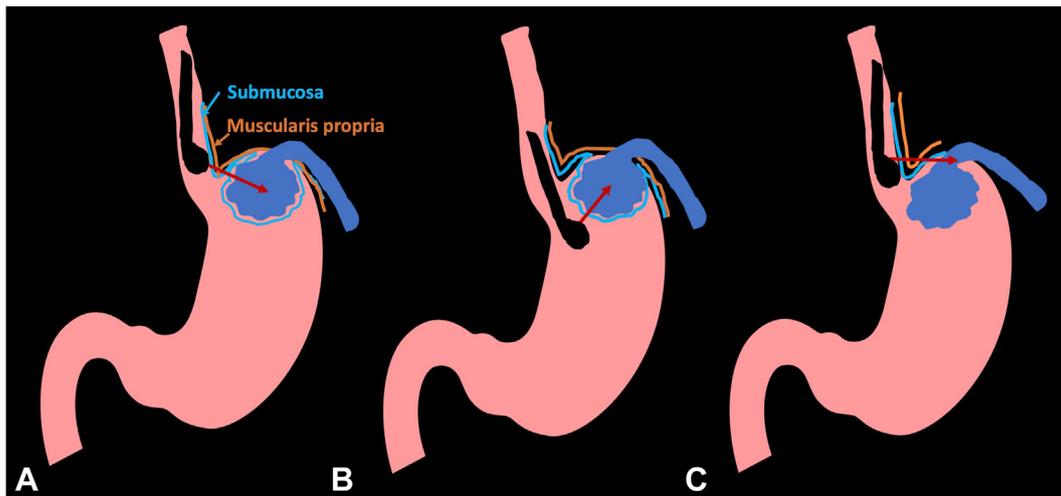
Various approaches of EUS-guided gastric variceal therapy. A, EUS-guided embolization of gastric varices via transesophageal (transmuscularis propria) approach: direct puncture of the varix and embolization technique. B, EUS-guided embolization of gastric varices via transgastric (trans-submucosal) approach by directly puncturing the varix. C, EUS-guided embolization of gastric varices by feeder vessel embolization via transesophageal (transmuscularis propria) approach.
